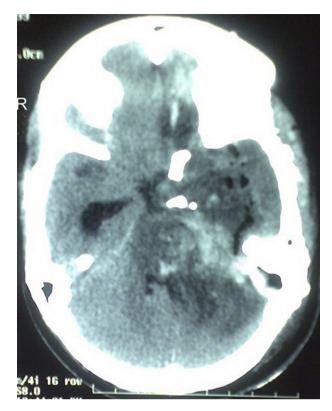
Post operative CT scan shows brainstem contusions and hypodensities with extraaxial blood in the left brainstem cisterns.
